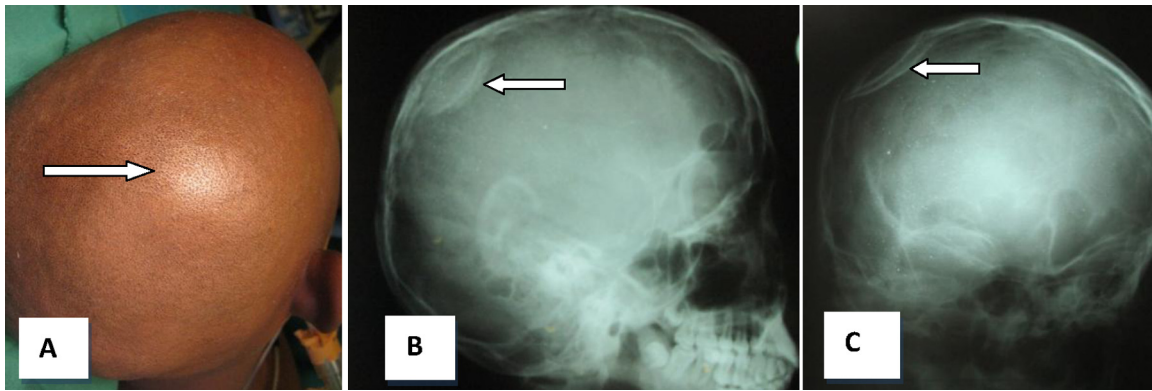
On the right (A), note parietal Cephalhematoma law (white arrow). On the left (B) and (C), conventional radiographs of the head showed a depression of the right parietal bone (white arrows).
